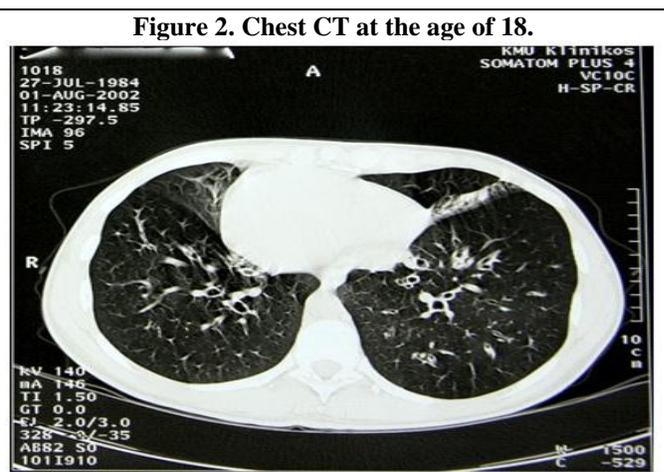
Chest CT at the age of 18.
